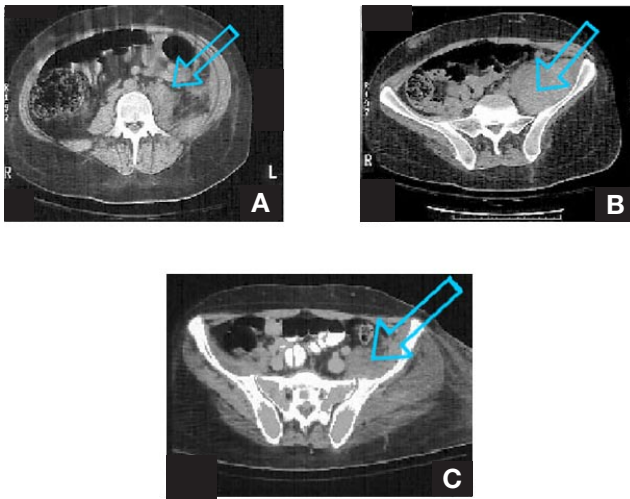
In case 1, computed tomography (CT) scans obtained on admission revealed (A) large inflamed psoas muscle extending into pelvis and (B) very large inflamed iliacus muscle extending into pelvis. (C) CT scan obtained 17 days later revealed no obvious loculated fluid collection. Left psoas and gluteal muscles appeared somewhat larger.
